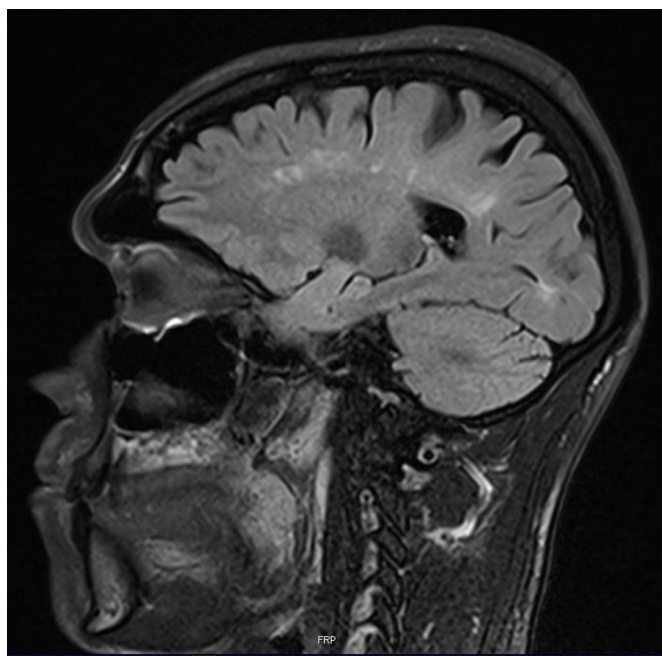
Brain MRI images showing T2-Fluid-Attenuated Inversion Recovery (FLAIR) hyperintense lesions without gadolinium enhancement on *corona radiata*/semioval centres and cortical atrophy.
